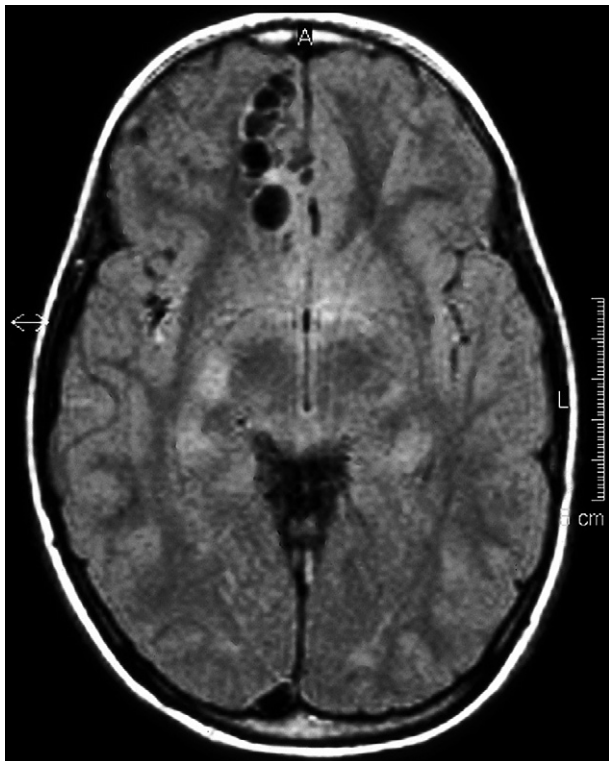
Axial fluid-attenuated inversion recovery magnetic resonance image (TR/TE/TI = 6000/140/2000 ms). The cysts are isointense with cerebrospinal fluid.
